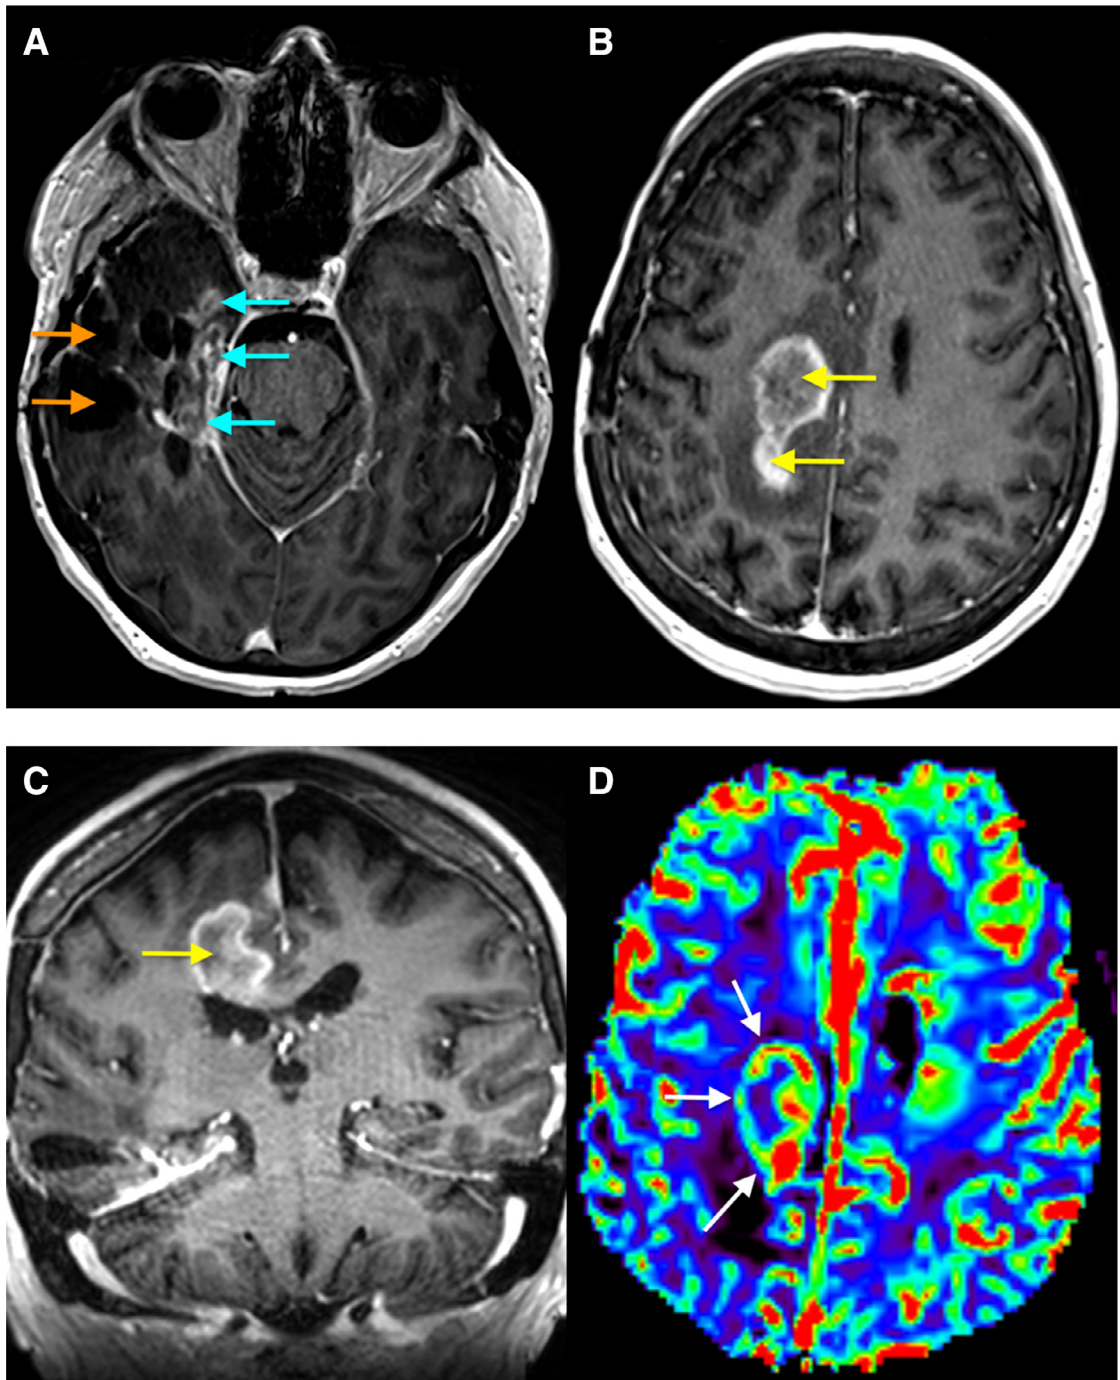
MRI of the brain 12.5 months after presentation. (A) Gadolinium-enhanced T1-weighted image showing local recurrence (blue arrow) and cystic encephalomalacia of the resection cavity (orange arrow). (B-C) Additionally, a contrast-enhancing mass (yellow arrows) was present in the right superior frontal gyrus and body of the corpus callosum. (D) Perfusion-weighted image showing an increased rCBF (white arrows) in the area of the frontocallosal mass. (E-F) T2-FLAIR-weighted images showing hyperintensity of the mass (red arrow) with significant perilesional edema (green arrows) extending to the precentral gyrus (purple arrow) and to a lesser extent to the postcentral gyrus (brown arrow), providing a possible explanation for the patient's progressive left-sided hemiparesis.
